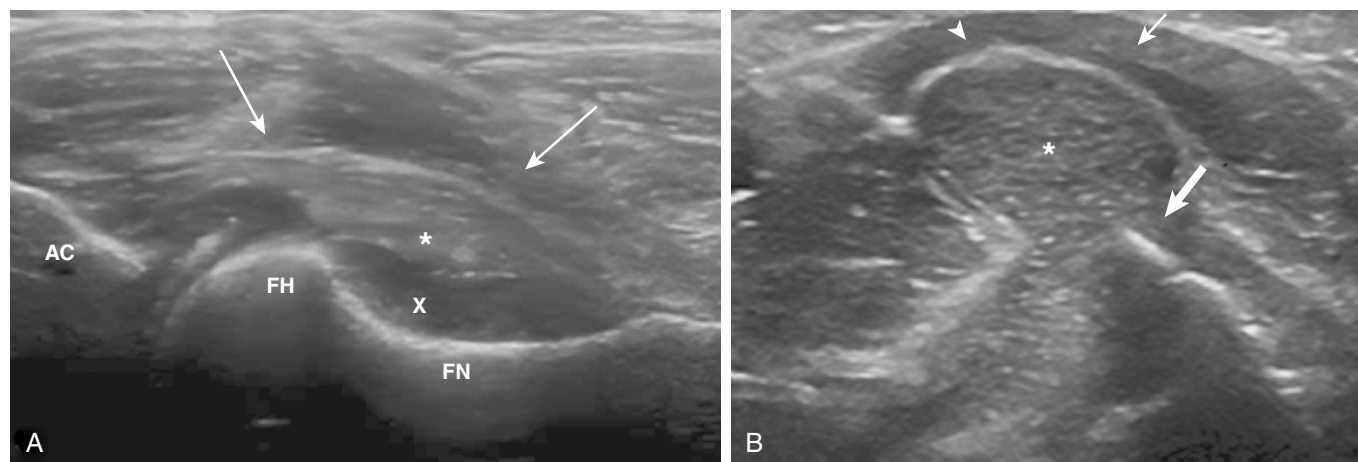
Ultrasound demonstrates the hip (A) and elbow (B) joints in patients with osteoarthritis. The 12-MHz ultrasound images show joint effusion (X), synovial thickening (stars) that determines joint capsule distention (arrows), and osteophytes (arrowhead). AC, acetabulum; FH, femoral head; FN, femoral neck.
